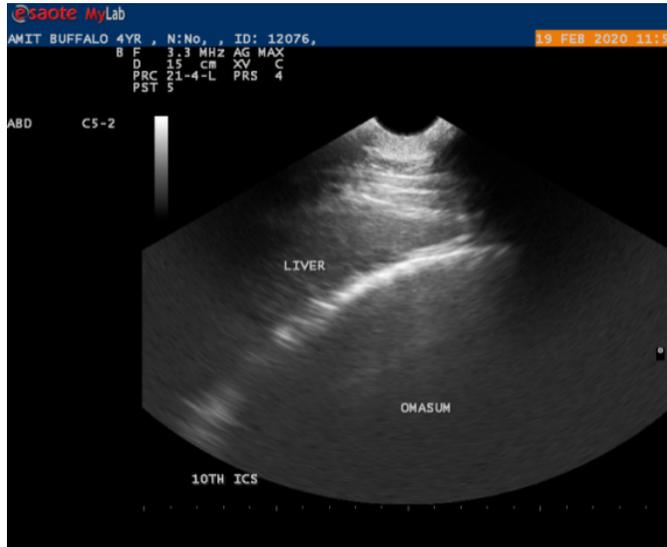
Sonogram of liver at 10th ICS showing homogenous coarse echogenic hepatic parenchyma, anechoic pear shaped gall baldder (GB) and half moon shaped omasual margin at ventral margin of the liver.
